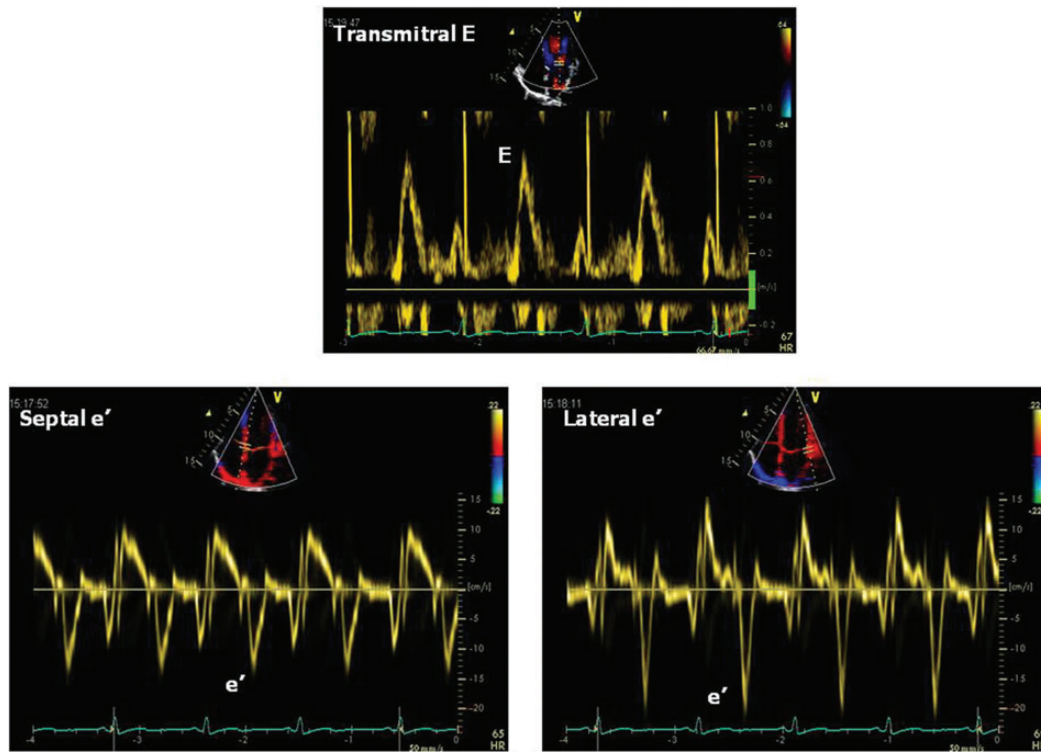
Methodology to calculate the ratio between standard Doppler derived transmitral early diastolic velocity (E) and pulsed Doppler derived early diastolic velocity of the mitral annulus (e'). The e' velocity can be measured either at the septal site or at the lateral site of the mitral annulus. However, recommendations on LV diastolic function encourage the average of septal and lateral e' velocities.
